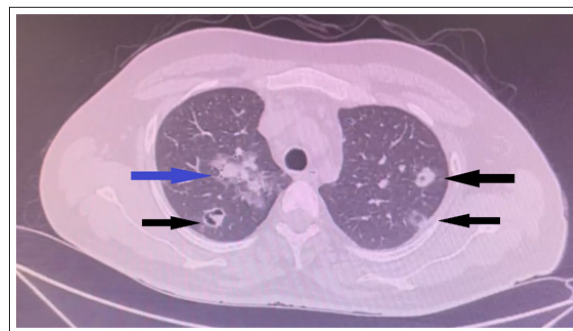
CT Scan of the Patient Showing Multiple thick-Walled Cavities (Black arrow) and a Heterogenous Opacity in the Right Hilar Area (Blue Arrow)
